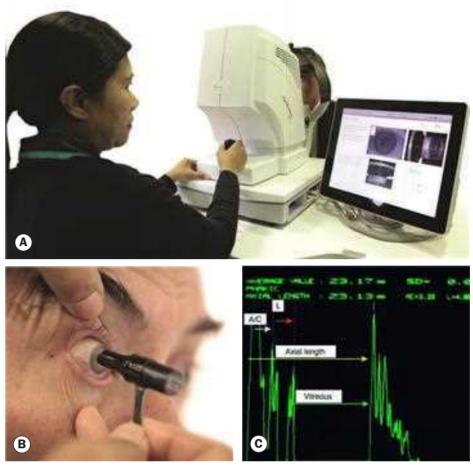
Biometry. (A) Optical coherence biometry; (B) contact ultrasonic biometry; (C) ultrasonographic monitor display (A/C, anterior chamber depth; L, lens thickness)
